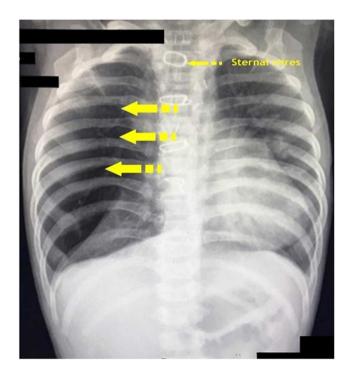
Chest X-ray Posteroanterior view demonstrating clear hyperlucency of the right middle lobe with crowding of the right upper and lower lobe with mediastinal shift. Sternal wires from the previous heart surgery can be observed.
